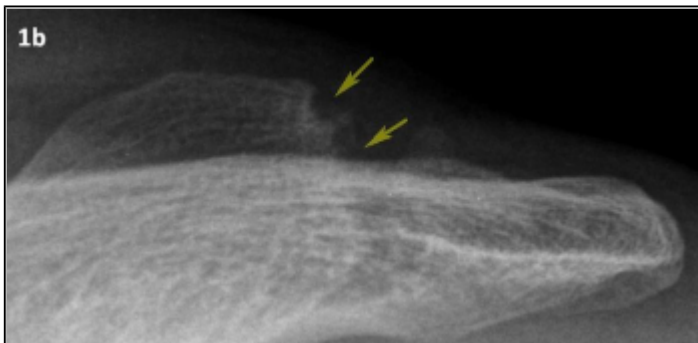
Conventional radiograph of the left shoulder
